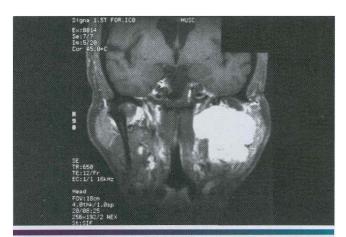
• Pleomorphic adenoma. TI -weighted. fat-suppressed, contrast-enhanced coronal magnetic resonance image (MRI) of a tumor of the deep lobe of the parotid gland. (Courtesy of Dr. Joel Cure.]
